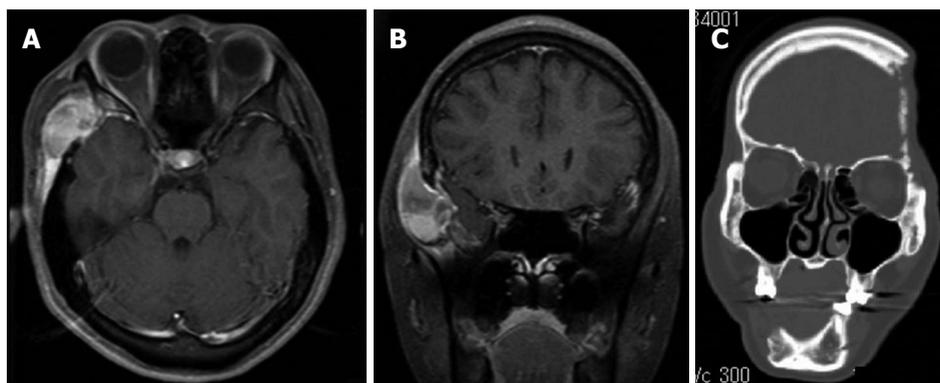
Langerhans cell histiocytosis skull mass (A, B) and lytic skull (C) lesion. A, B: Gadolinium-enhanced magnetic resonance imaging (T1W1) shows a mass with heterodensity at the right temporal area. axial view (A), coronal view (B); C: Computed tomography scan shows extensive lytic bones, at the left temporal bone and mandible. Defect of the right mandible is due to surgical resection.
